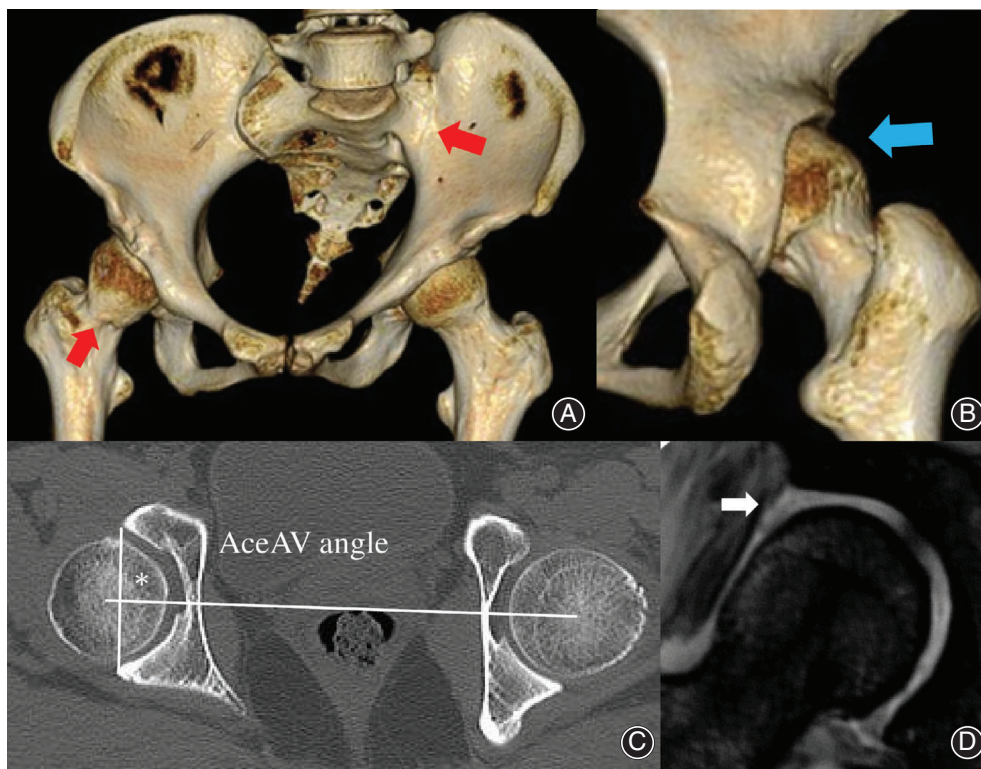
Preoperative computed tomography (CT) and magnetic resonance images. (A) Three-dimensional CT images showing left sacroiliac joint fusion and cam lesions in the right femoral neck in the right hip joint (indicated by red arrows). (B) Insufficient coverage of the posterior acetabulum owing to developmental dysplasia of the hip and acetabular retroversion (indicated by the blue arrow). (C) Axial CT image showing acetabular retroversion of 1° in the right acetabulum. (D) Magnetic resonance image showing a change in brightness in the anterolateral region of the labrum of the right acetabulum, suggesting a labrum tear (indicated by the white arrow). AceAV angle, acetabular anteversion angle.
